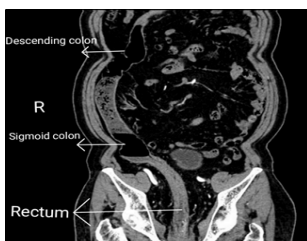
A Coronal MPR Image of CT Showing Right Sided Sigmoid Colon.
